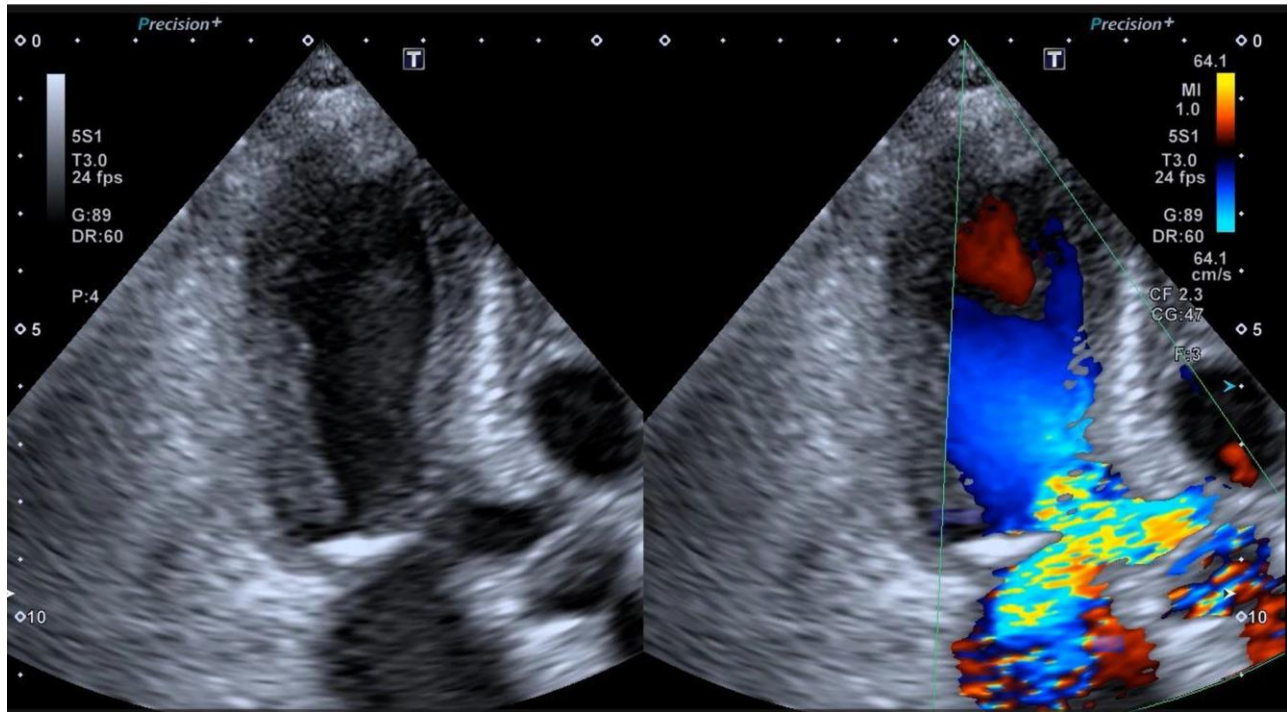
Transthoracic echocardiography performed 2 days after takotsubo syndrome onset at paroxysmal atrial fibrillation. Three-chamber view at systolic phase showing deterioration of left ventricular outflow tract obstruction and worsening mitral regurgitation.
